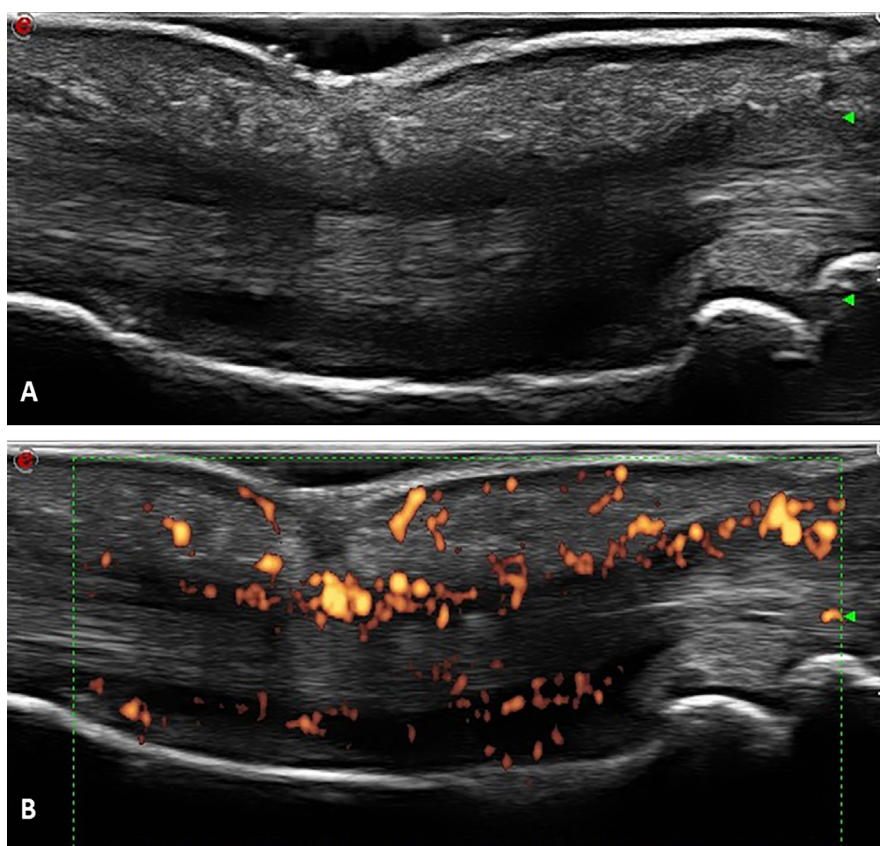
A: Grey scale and B: power Doppler of volar ultrasonography of hand psoriatic dactylitic digit showing flexor tenosynovitis and soft tissue oedema.
